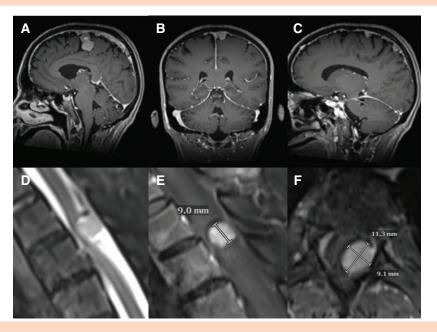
Radiographic findings. MRI brain—T1 contrast showing—axial, coronal, and sagittal sections of the Tumor 1 (A), Tumor 2 (B), and Tumor 3 (C) noted along the falx and parasagittal region. All lesions were resected through a single left parasagittal craniotomy and interhemispheric approach. MRI of the thoracic spine—Sagittal T2W (D), Sagittal T1W-Post Contrast (E), Axial T1-Post contrast (F) showing dural based intradural extramedullary mass extending from T2 to T3. The spinal cord is compressed by the tumor and displaced to the right as noted in the axial images.
